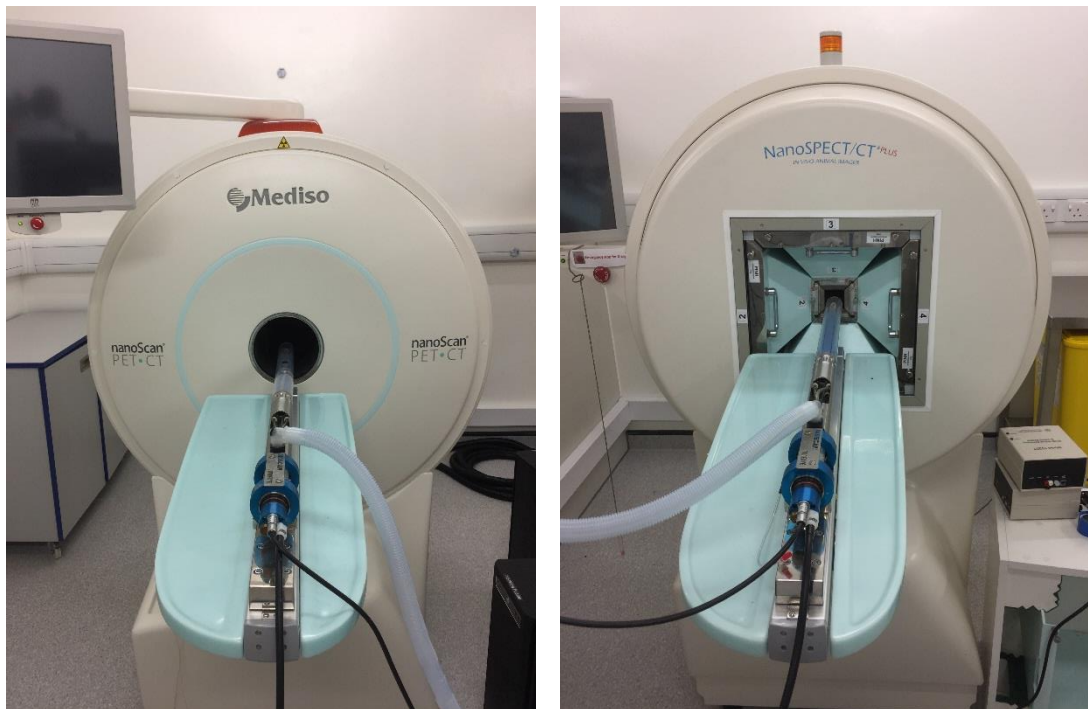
Photograph of (left) nanoScan PET-CT and (right) nanoScan SPECT-CT (Mediso Medical Imaging Systems, Budapest, Hungary) in the University of Nottingham preclinical imaging facility (SPOT).
